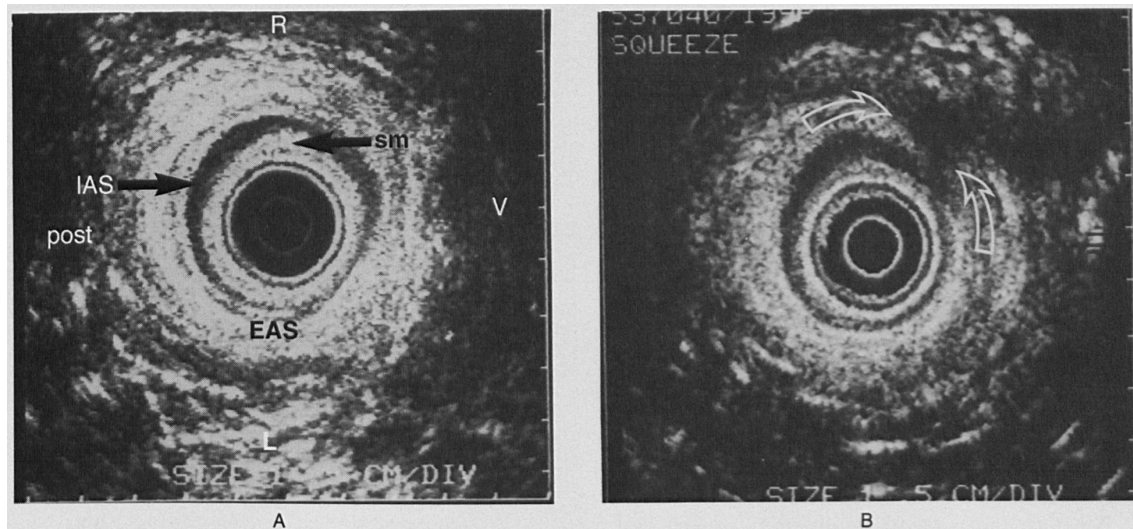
Results of Anal Endosonography before and after Delivery in a Primiparous Woman with a Postpartum Defect of the External Anal Sphincter.
